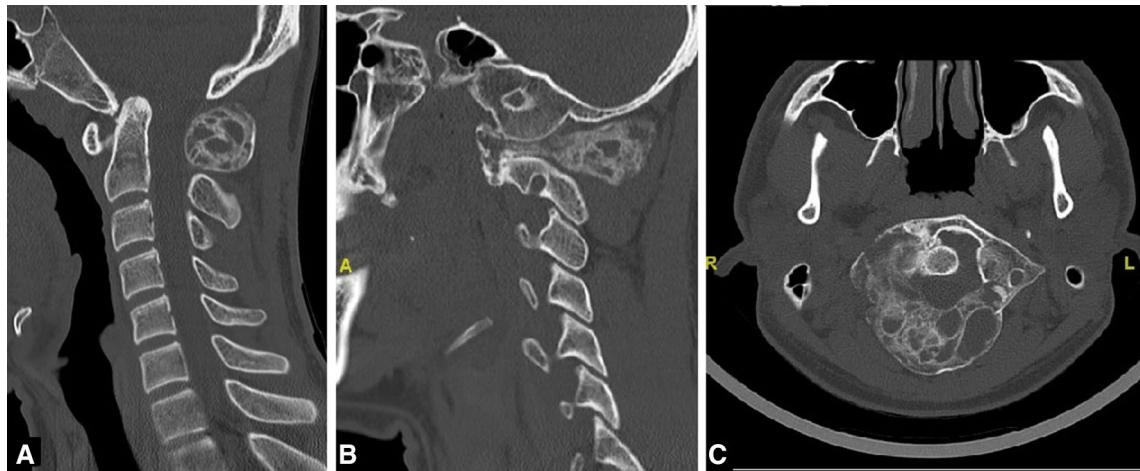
CT-Scan after 6 months of initiation of denosumab therapy suggestive of sclerosis and ossification of the ABC; there is radiological basilar invagination; a sagittal view b right parasagittal view, c axial view
